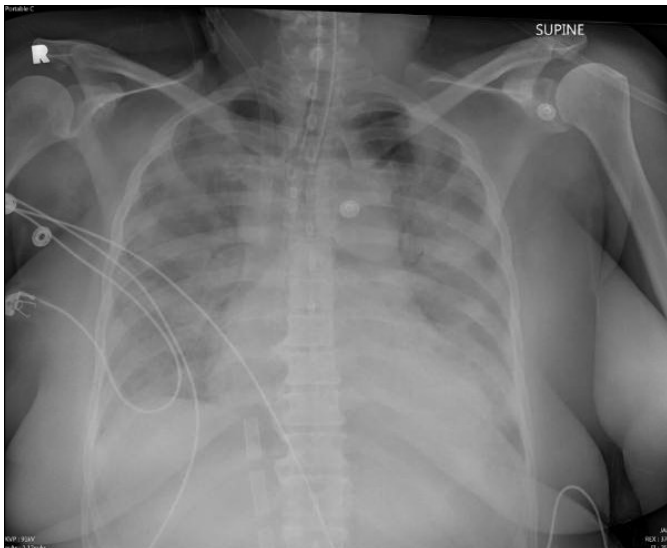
Chest X-ray on day of admission showing extensive diffuse airspace opacification with left retrocardiac opacification consistent with pulmonary edema, pulmonary hemorrhage, pneumonia, or ARDS.
